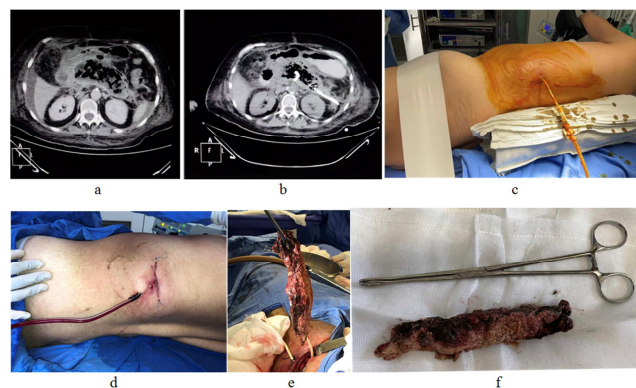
a. Admission CT; b. CT post percutaneous drainage; c. Presurgical position; d. Post-surgical wound and drainage; e and f. Surgical piece (necrotic pancreas).
